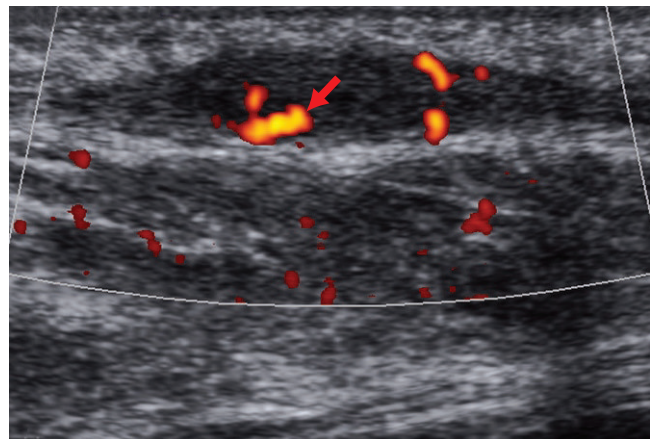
The longitudinal image of the plantar side of the foot shows a thickened, hypoechoic plantar fascia consistent with plantar fibromatosis; there is increased color Doppler flow within the area of fibromatosis (arrow).
